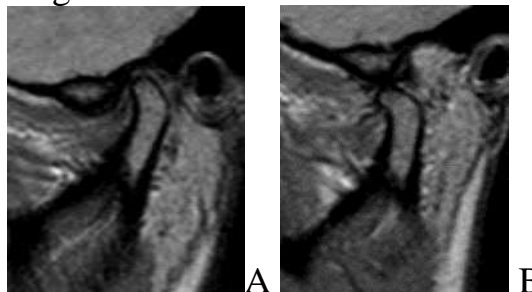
MRI-cuts of the TMJ in the skew-sagittal plane:
